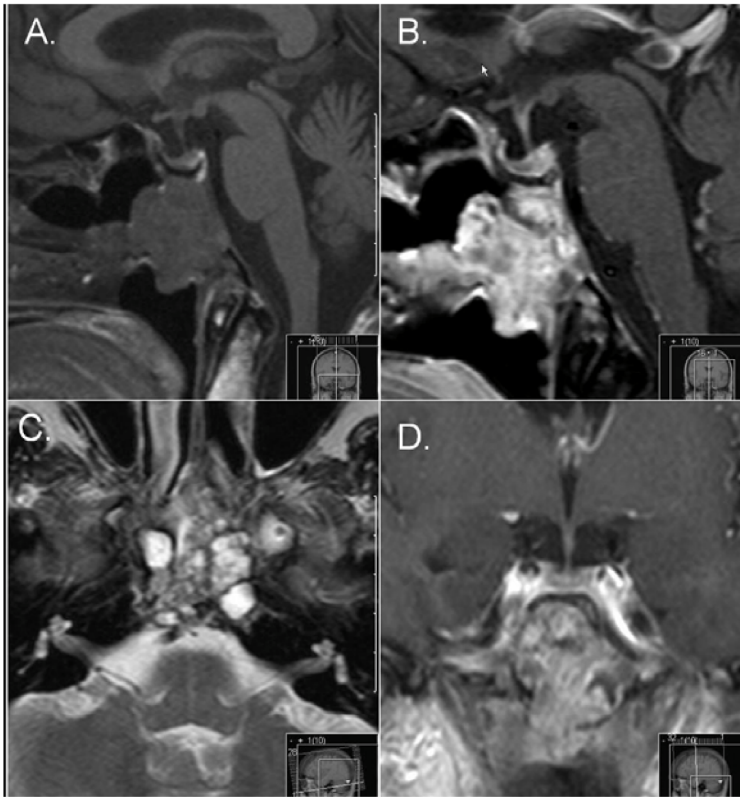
Magnetic resonance imaging (MRI) studies showing a clival mass measuring 2.5 x 2.2 x 2.0 cm (width x anterior–posterior x rostral–caudal). A. Sagittal, T1-weighted MRI exhibiting isointense clival mass with anterior extension into the posterior nasopharynx. B. Sagittal, T1-weighted MRI with gadolinium showing uniform enhancement of the clival mass. Note the normal appearance of the pituitary stalk and gland with no relationship noted between the sella and infrasellar mass. C. Axial, T2-weighted MRI exhibiting hyperintense lesion of clival mass. D. Coronal, T1-weighted MRI with gadolinium.
